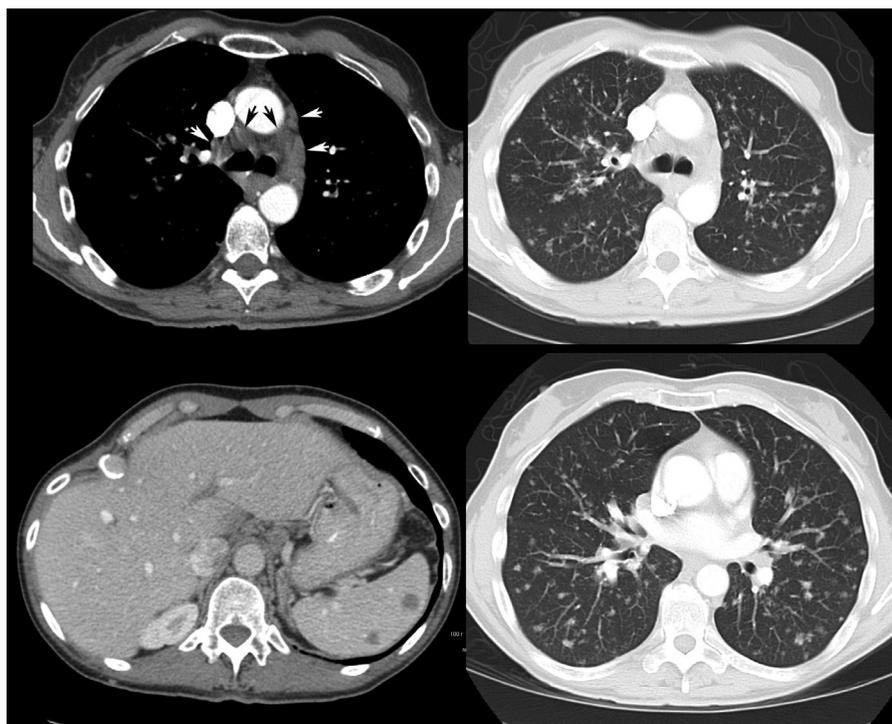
Follow-up diagnostic CT of chest/abdomen/pelvis performed 6 months later, again revealed extensive poorly marginated lung nodules, thoracic and abdominal lymphadenopathy, and splenic and hepatic hypodensities, unchanged as compared to prior PET/CT and consistent with stable granulomatous disease. The patient was managed conservatively with observation and remained malignancy-free over the subsequent 9 years of clinical and imaging follow-up. Sarcoidosis is a chronic multisystem granulomatous disorder of unknown etiology, which is characterized pathologically by non-caseating granulomas that can present almost anywhere in the body (1,2,3,4). ^{18}F -FDG uptake in the granulomas of sarcoidosis can be very intense, likely due to metabolic activity of activated macrophages (2,3,5). ^{18}F -FDG-avid lesions of skeletal sarcoidosis cannot be reliably differentiated from metastases or other benign bone processes (Paget's disease, fibrous dysplasia, giant cell tumors, osteomyelitis) on the basis of semi-quantitative (SUV), visual or other analysis, and therefore remain a pitfall of oncologic PET/CT interpretation (6,7,8,9,10). ^{18}F -FDG uptake in pulmonary sarcoidosis lesions has been described and the severity of pulmonary involvement has been shown to be associated with ^{18}F -FDG activity in persistently symptomatic sarcoidosis patients (11). CT studies show presence of hepatic and splenic nodules in approximately 5-15% of sarcoidosis patients and splenic nodules tend to be larger than hepatic nodules (12). Intense ^{18}F -FDG uptake in hepatic and splenic sarcoidosis lesions has been previously described (13). This case shows an uncommon presentation of disseminated sarcoidosis in the skeleton, lymph nodes, as well as organs such as the lungs, liver and spleen. This impressive pattern of disseminated ^{18}F -FDG uptake can be easily mistaken for extensive metastatic disease when interpreting oncologic PET/CT studies.
